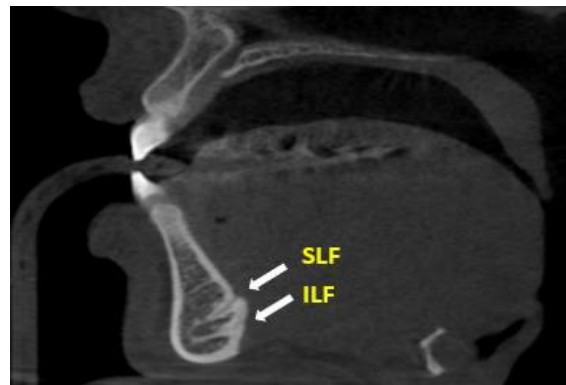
CBCT sagittal plane showed superior and inferior lingual foramen (SLF & ILF).
